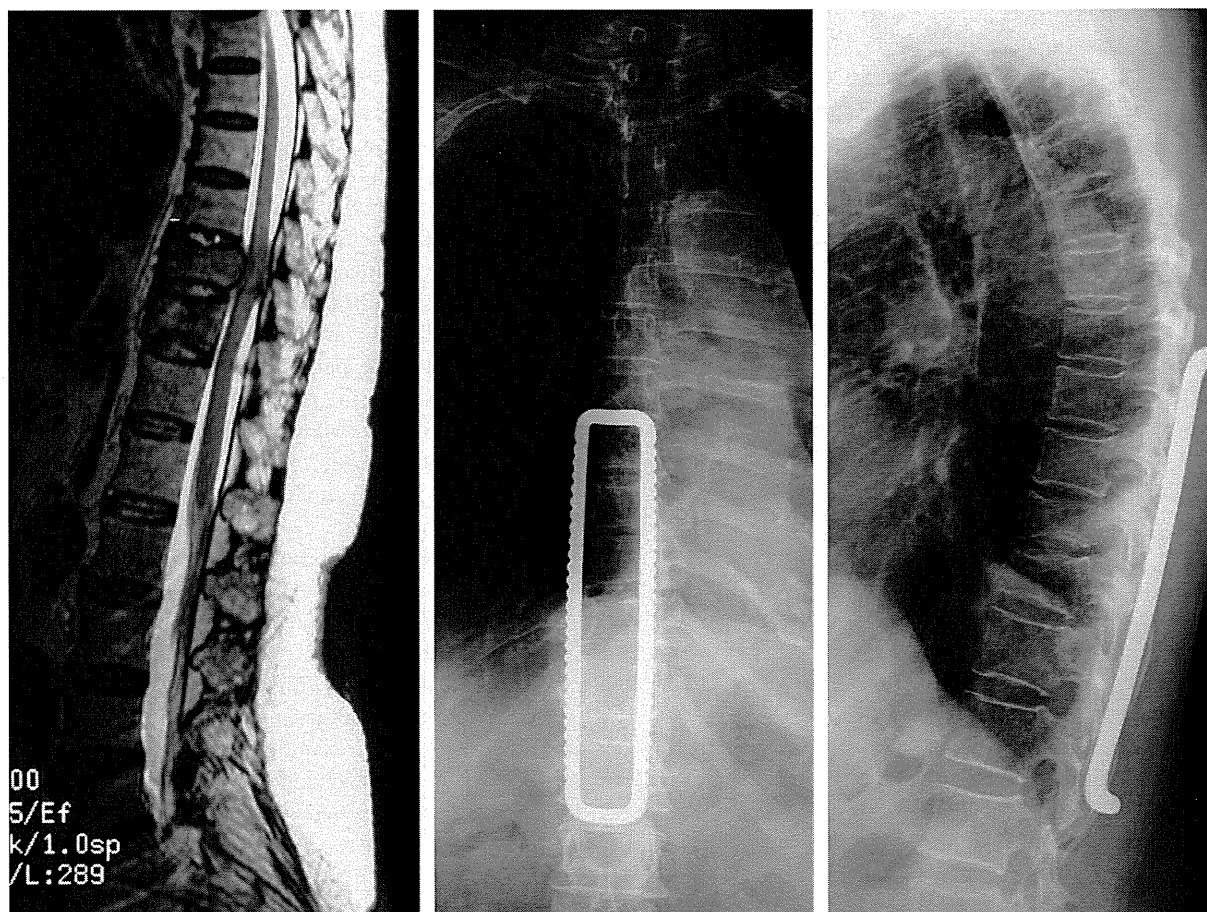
Seventy-three-year-old female with Frankel C paraparesis from lung cancer metastasis. (Left) Preoperative magnetic resonance T2WI-sagittal image demonstrates severe thoracic spinal cord compression at Th10 level. (Middle) Postoperative anteroposterior and (Right) lateral X-ray images. Circumferential decompression was performed via the posterolateral route by laminectomy at Th9 to Th11 combined with posterior stabilization using a rectangular rod.
